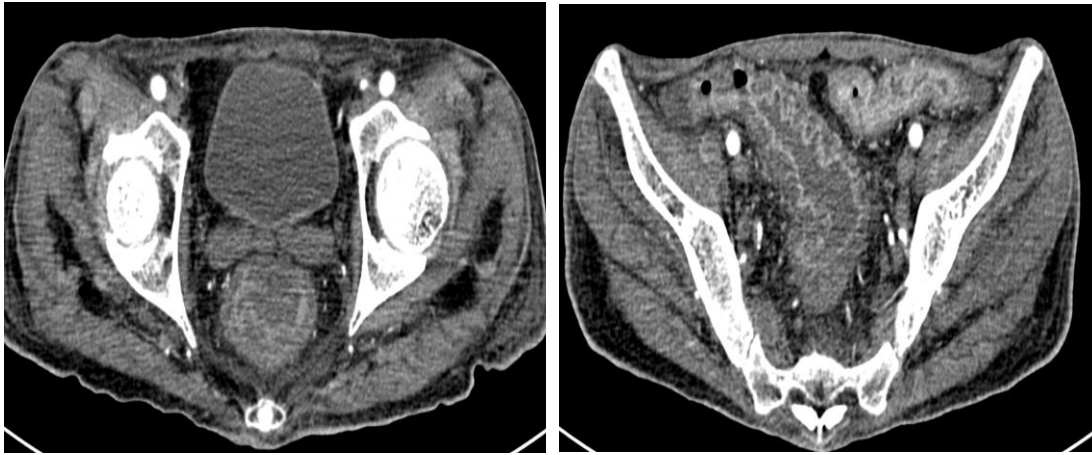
CT images showing inflammatory thickening of the recto-colic wall.
